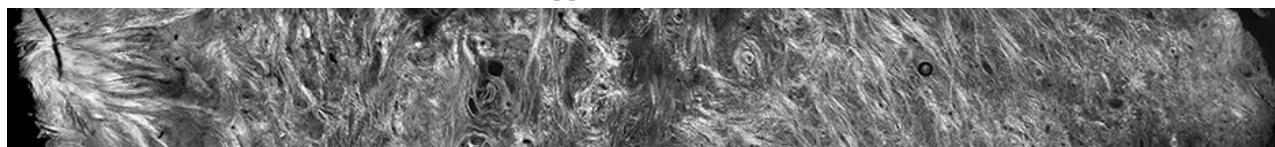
We detect the alignment of collagen within layers in this SHG image of cervix using ultrasound. The cervical canal is on the right and the ectocervix (outer edge) is on the left.
